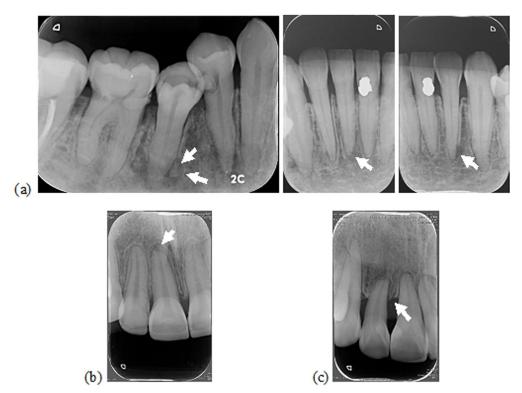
Periapical radiograph of the combination of bone sclerosis and bone destruction around the teeth and alveolar crest and the widening of the PDL space in patients who had a history of radiation therapy for cancer in the base of the tongue (a). The periapical film of patients with periapical disease in the anterior maxillary teeth due to accidental trauma showing a radiolucent and widening PDL at the apex of the root (b). In another case, the periapical film of a patient with periodontal disease in the right lateral maxillary teeth due to traumatic occlusion showed horizontal bone loss of the alveolar crest (c)
